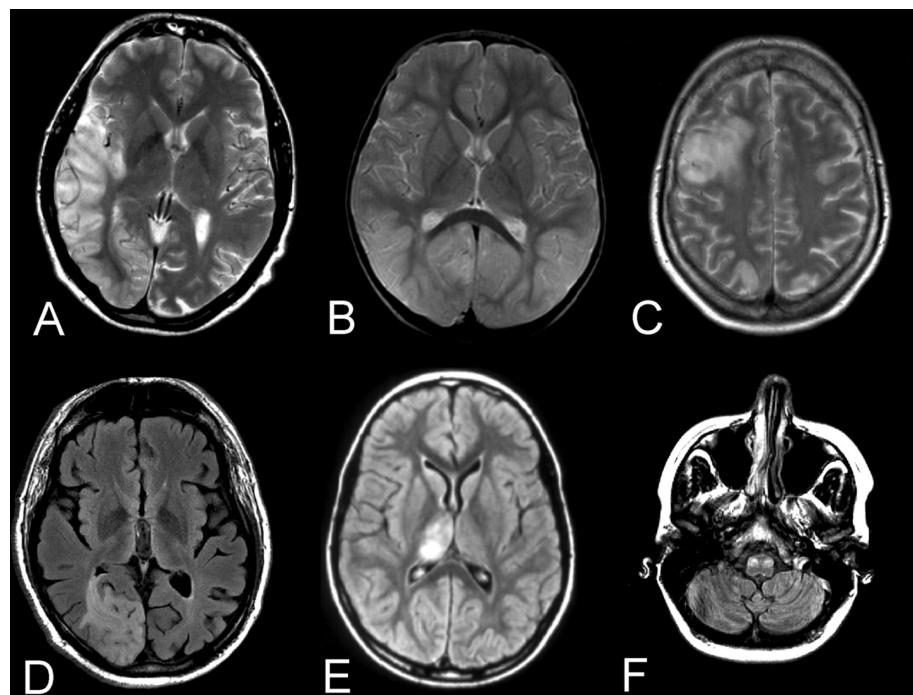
MRI images. (A) T2-weighted image showing a right temporo-occipital high signal lesion (fresh, edematous cortex) in MELAS. This is a typical finding in this disorder and is what can be called a stroke-like lesion. Patient with *m.3243A > G* mtDNA mutation. (B) T2-weighted image showing bilateral temporo-occipital, cortical, high signal lesions in a child with Alpers' syndrome and mutation in *POLG*. (C) T2-weighted image showing right frontal and parieto-occipital and left frontal high signal lesions from a patient with mitochondrial spinocerebellar ataxia and epilepsy (MSCAE) during an episode of status epilepticus and encephalopathy. (D) T2-FLAIR image showing a right occipital high signal lesion developing in a patient with MSCAE and status epilepticus. (E) T2-FLAIR image showing a right thalamic high signal lesion. These are typical for MSCAE and persist in contrast to the lesions depicted in (B), (C), and (D) which are evanescent. (F) T2-FLAIR image showing bilateral inferior olfactory high signal lesions. These too are typical for MSCAE, but only one patient had the clinical correlate of palatal myoclonus.
